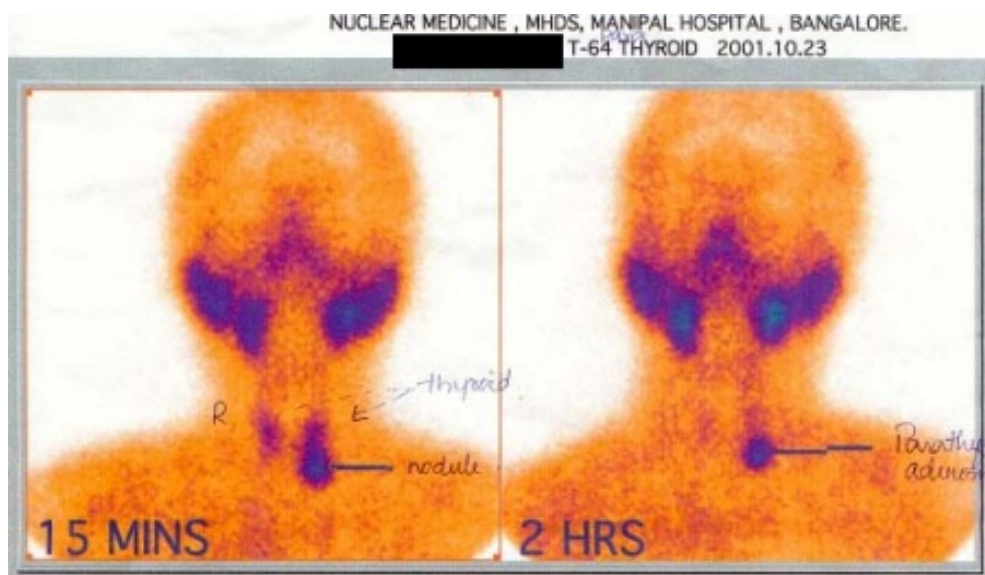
Thallium subtraction scintigraphic localisation of a parathyroid adenoma
